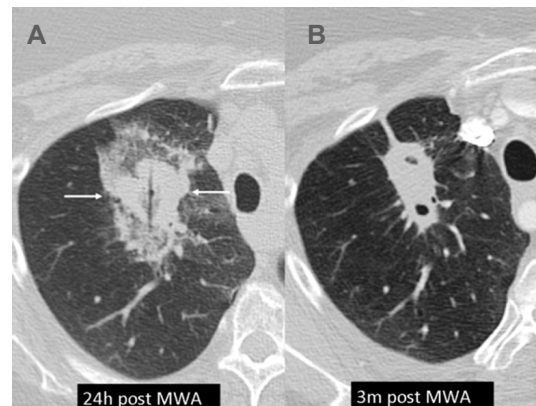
57-year-old female with right upper lobe squamous cell carcinoma. Axial CT scan lung windows. A: 24 h post microwave ablation showing surrounding GGO, most narrow GGO zone medially and laterally (arrows); B: 3 months post microwave ablation showing satisfactory shrinking of ablation zone, small central cavities. GGO: ground-glass opacity
